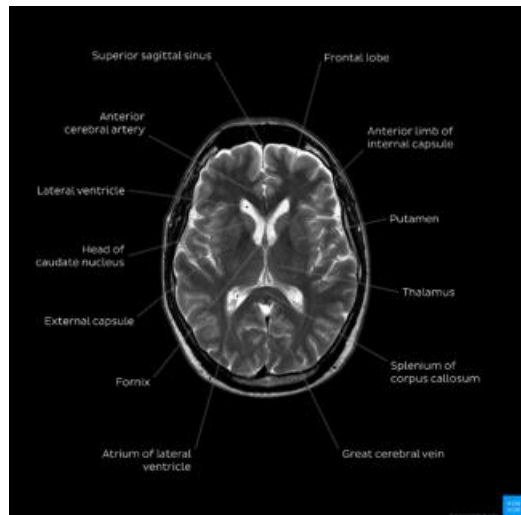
MRI of Normal Brain
